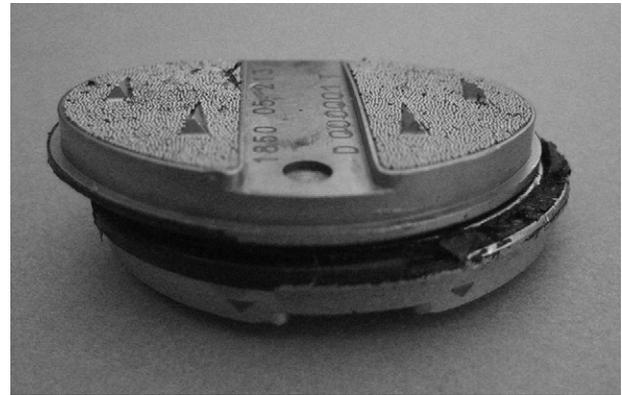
Catastrophic failure of the AcroFlex lumbar disc replacement (LDR) at L4/L5 revised initially to instrumented posterolateral fusion. However, progressive osteolysis adjacent to the implant prompted removal of the device (Top) and conversion to anterior lumbar interbody fusion with a carbon-fiber cage. Coronal and sagittal computed tomography scan (Bottom) with solid arthrodesis at L4/L5. Note intact AcroFlex LDR at L5/S1.
